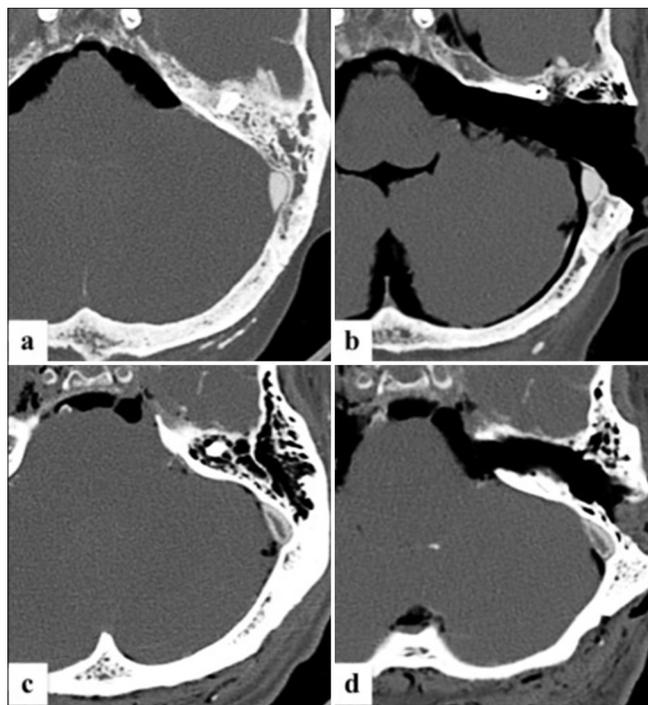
Pre- and post-procedural cranial computed tomography scans showing the variation of the presigmoid retrolabyrinthine suprameatal approach (PRSA) corridor and the exposure of preopontine territory based on petrous bone orientation, petroclival angulation, and the type of sigmoid sinus location: (a and b) pre- and post-procedure examples of obtuse petrous angulation with a straight operative trajectory to the central preopontine area; (c and d) pre- and post-procedure examples of acute angulation with a relatively limited surgical corridor. The sigmoid sinus was not exposed in any case.
